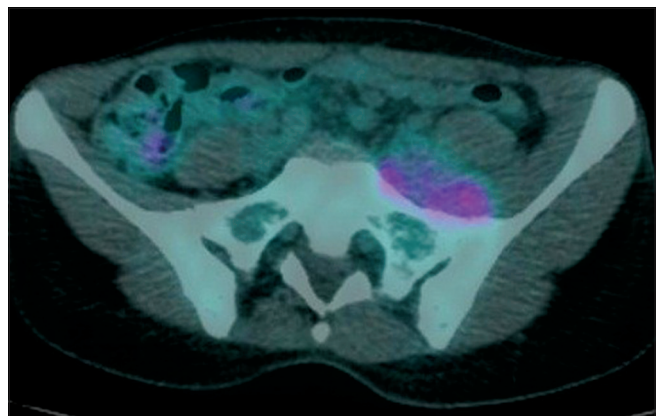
Fused transaxials of ^{18}F -FDG PET/CT showing inhomogeneous increased FDG uptake (SUVmax 4.8) to the front edge of the left sacral wing
